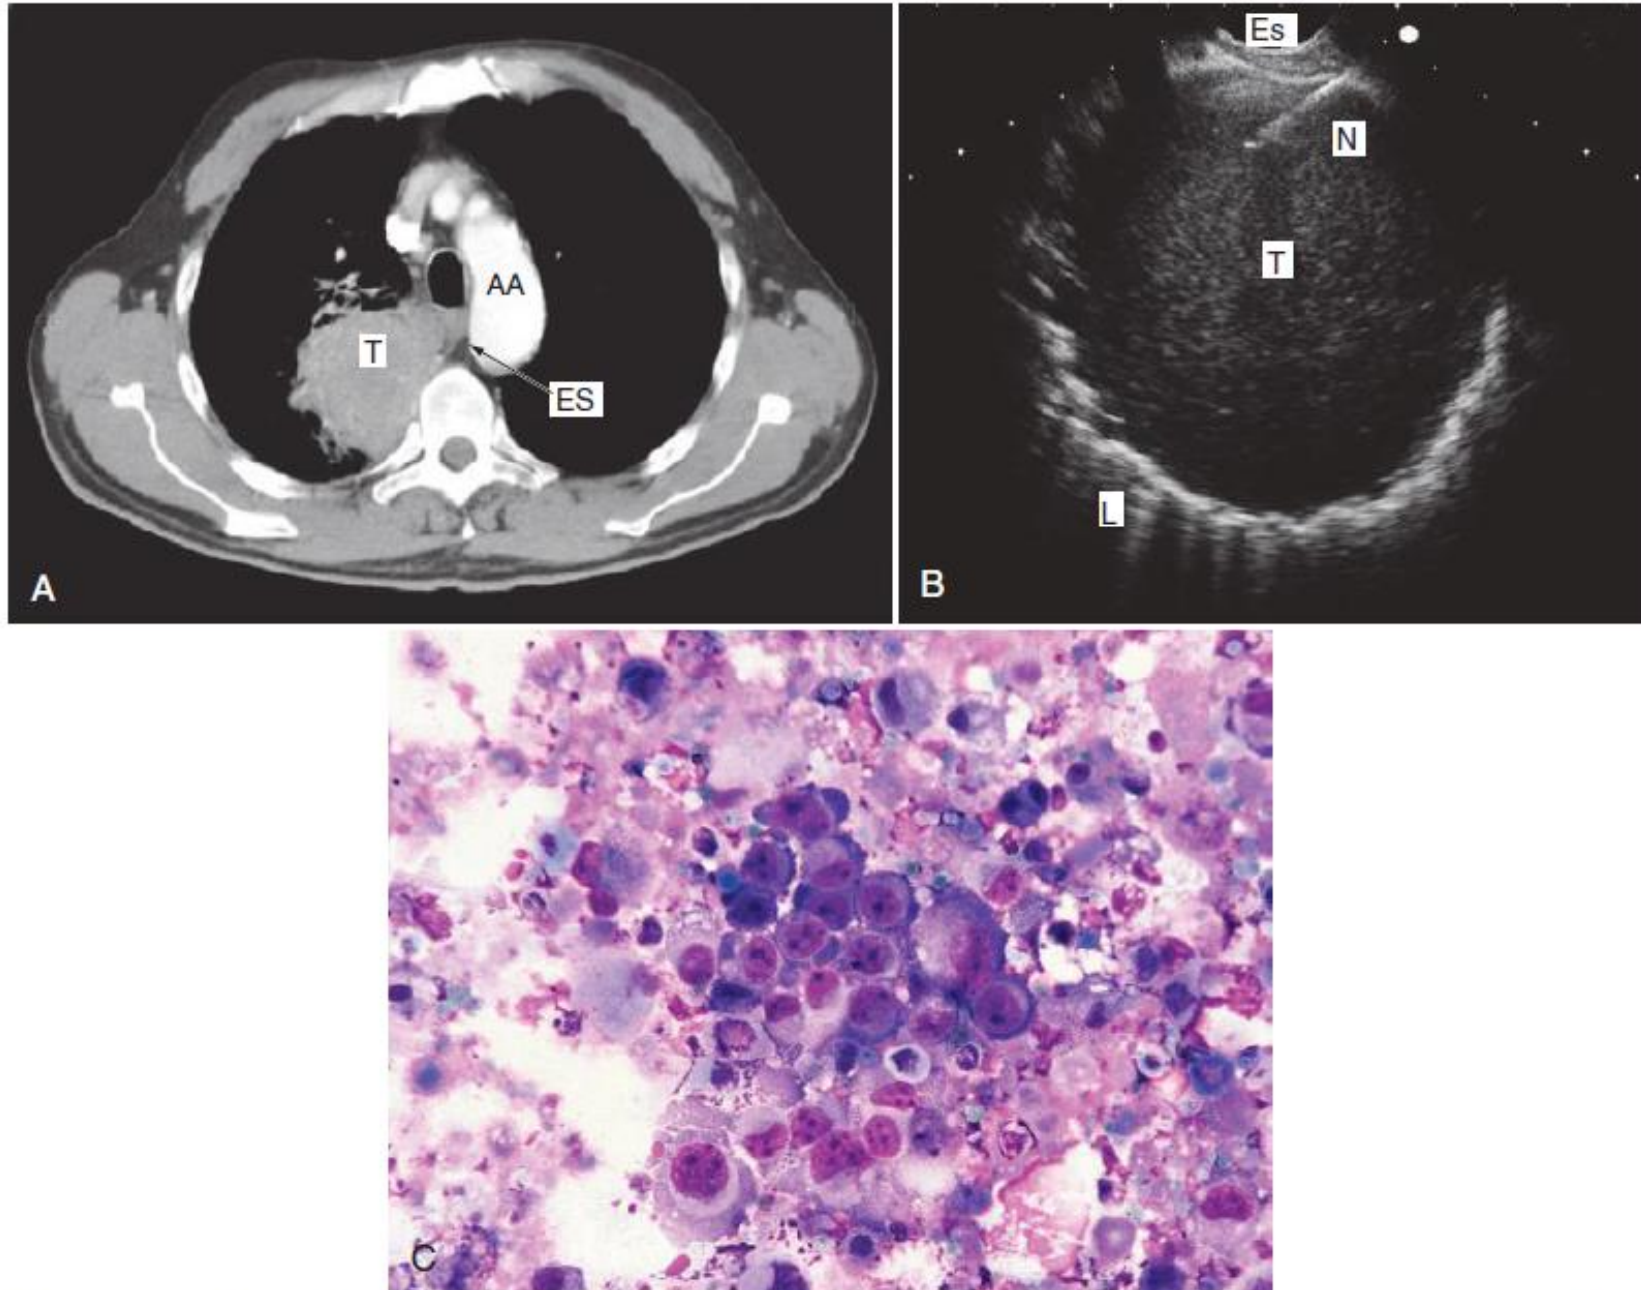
A 53-year-old smoker with suspected lung cancer in whom bronchoscopy did not establish a diagnosis. A, Computed tomography of the chest demonstrating an intrapulmonary tumor (T) in the right upper lobe located adjacent to the esophagus (ES). AA, aortic arch. B, Corresponding EUS fine-needle aspiration image. Notice the needle (N) located in the tumor (T). Es, esophagus; L, compromised lung tissue. C, Cytology of fine-needle aspirate demonstrating a squamous cell carcinoma.
